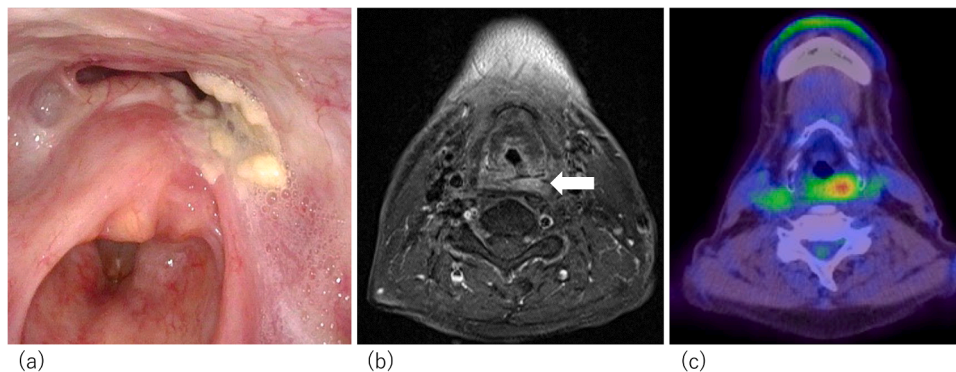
Flexible laryngoscopy demonstrated a tumor in the left piriform sinus of the hypopharynx (a). Contrast-enhanced cervical magnetic resonance imaging (MRI) revealed a lesion at the site indicated by the arrow (b), with corresponding fluorodeoxyglucose uptake on FDG positron emission tomography (PET) (c).
